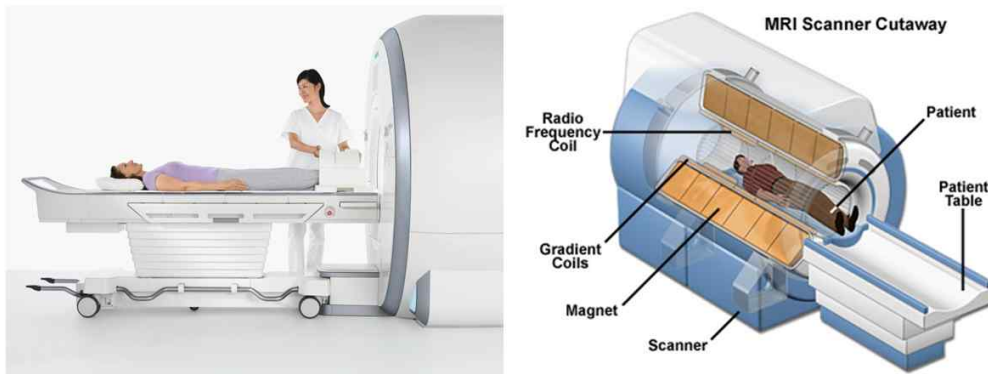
MRI Scanner and principles (image from PANOPTES)
